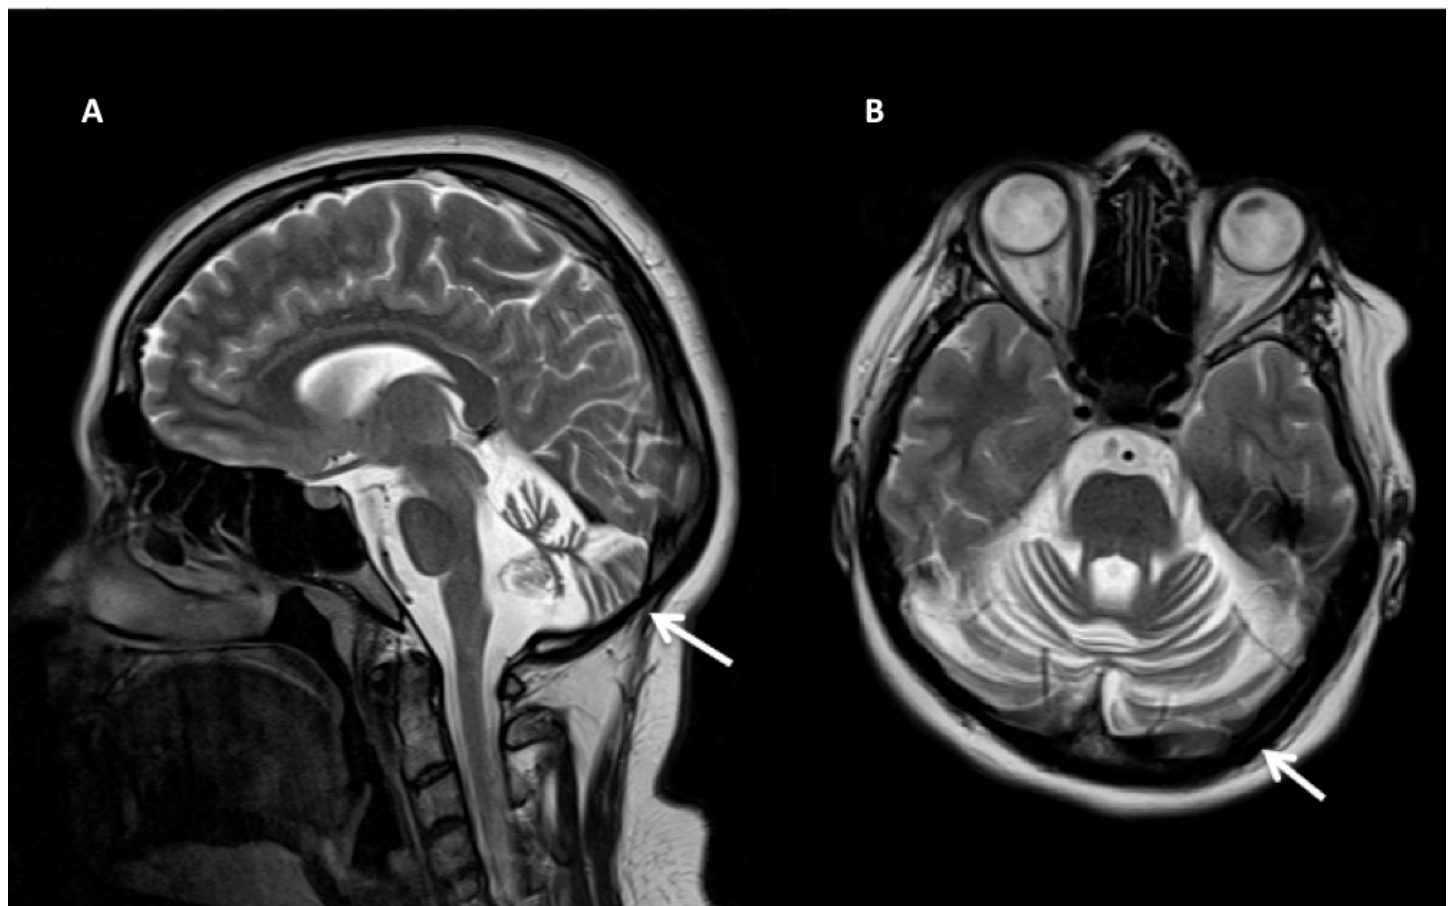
Magnetic resonance brain imaging. Sagittal (A) and axial (B) T2-weighted brain imaging demonstrating diffuse cerebellar atrophy.
